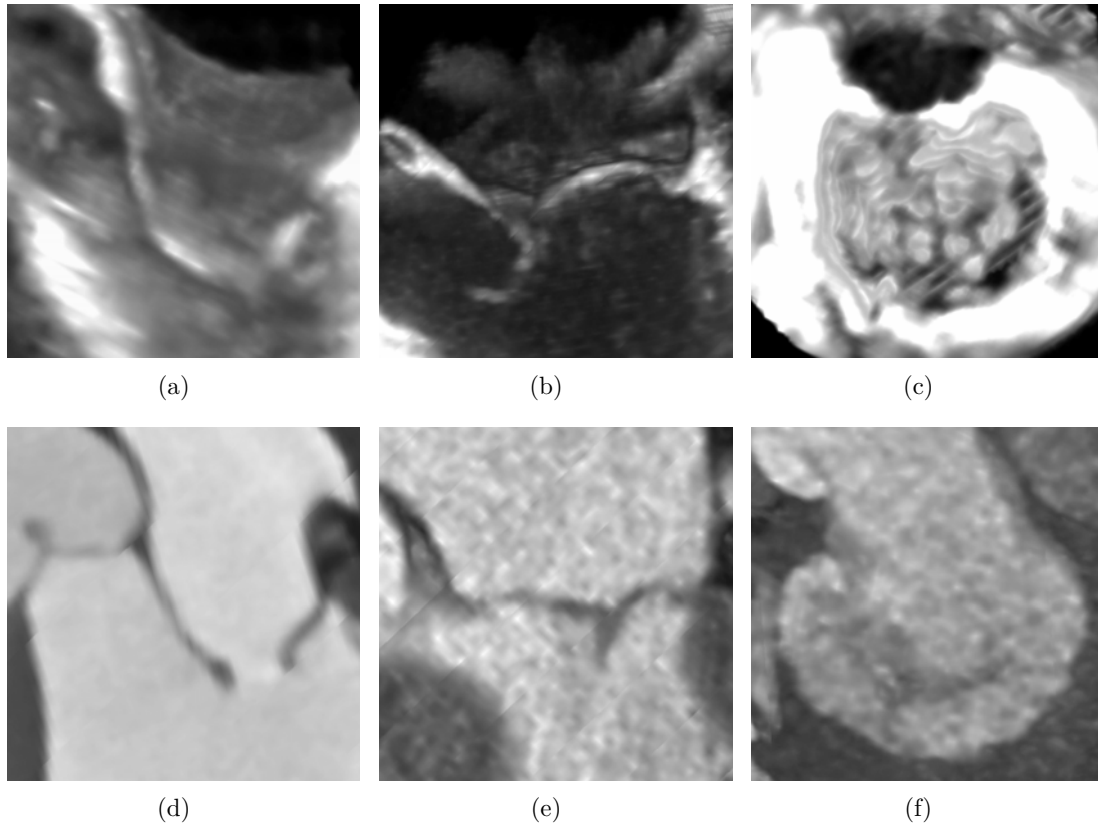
Examples of mitral valve disease: stenotic mitral valve from TEE (a) and CT (d), mitral valve prolapse from TEE (b) and CT (e), and mitral valve regurgitation from TEE (c) and CT (f).
